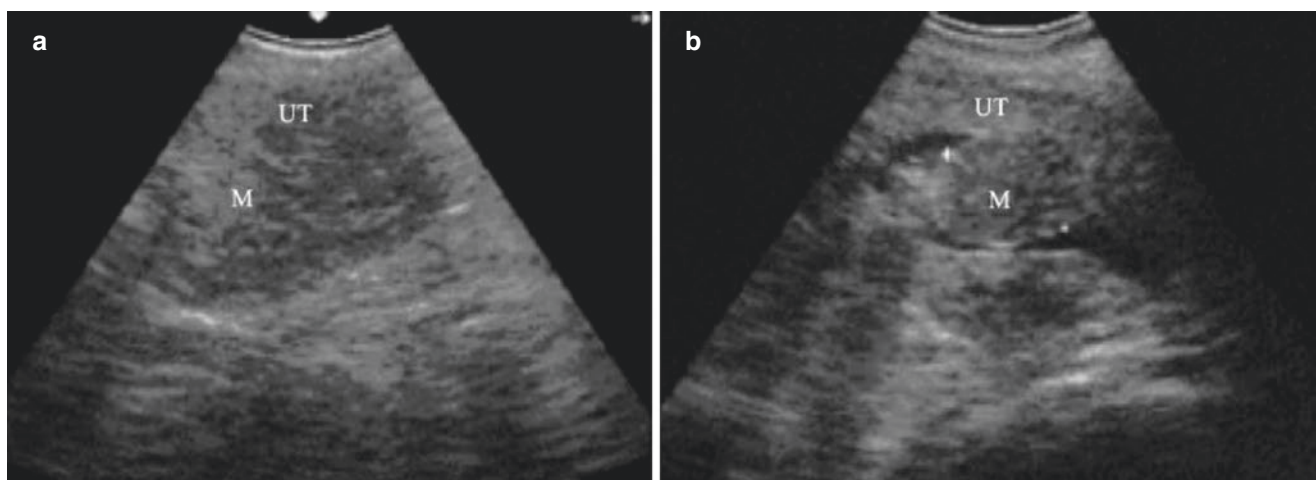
Sonohysterography of submucosal uterine myoma (I). (a) The patient is 60 years old. Sonogram shows the slightly hypoechoic occupation in the uterine cavity, with unclear boundary.
